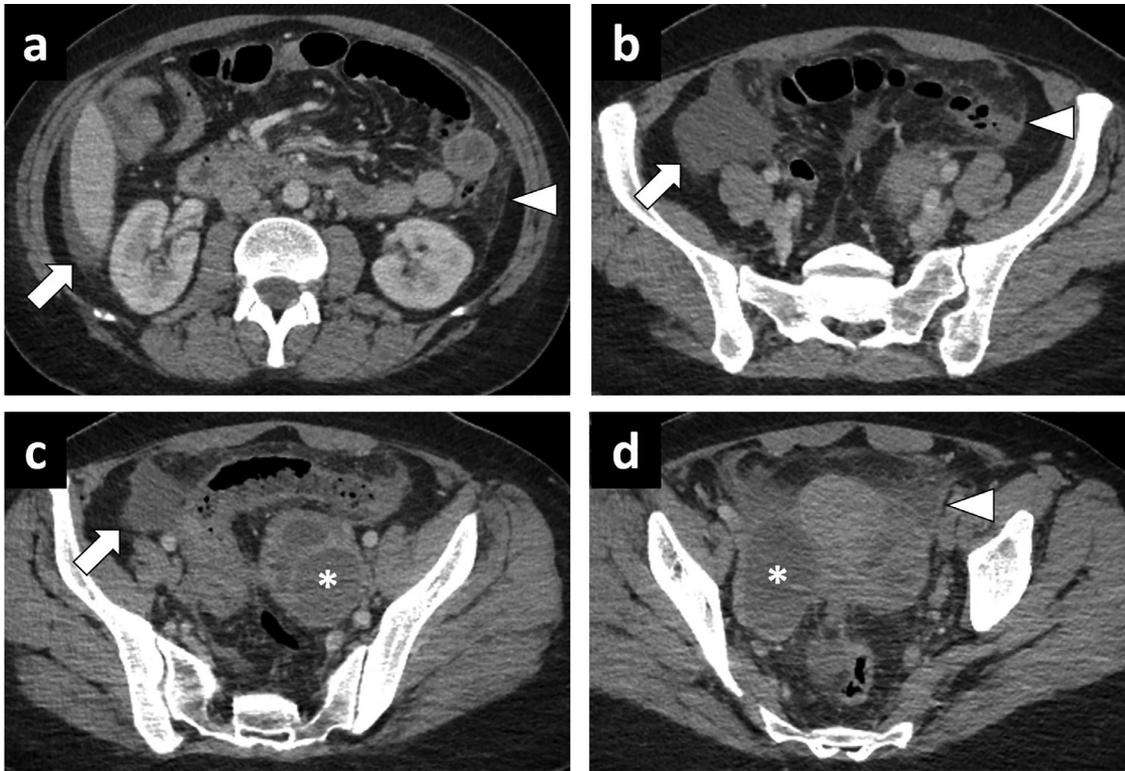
Clinical progression and development of peritonitis on day 3 (A–D) Consecutive axial postcontrast abdominal CT images from superior to inferior show intraabdominal free fluid (arrows, A, B, and C), peritoneal thickening (arrowheads, A, B, and D), extensive pelvic fat stranding (D), and bilateral cystic adnexal lesions with enhancing thick walls (asterisks, C and D).
